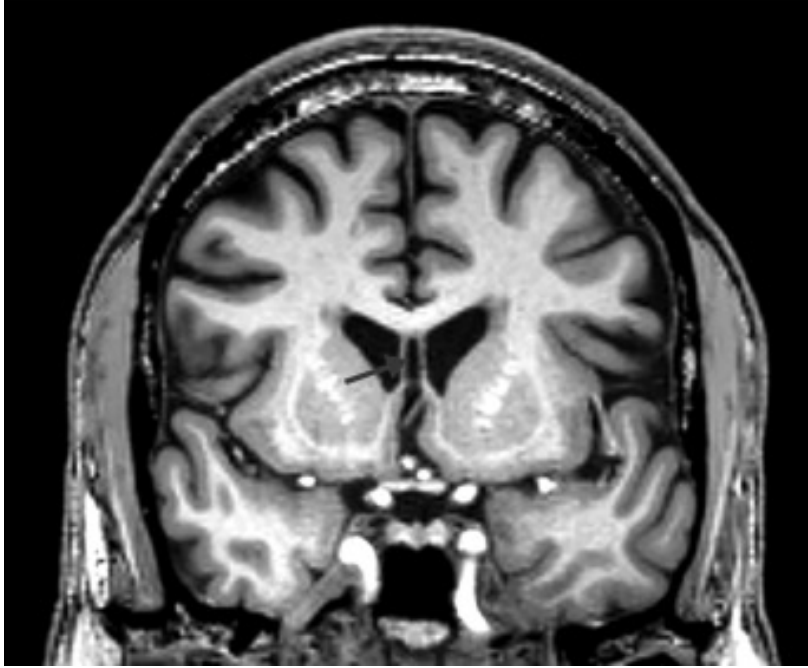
Cavum septi pellucidum on coronal plane of T1-weighted MRI of symptomatic, former professional football player, marked by an arrow (59).
